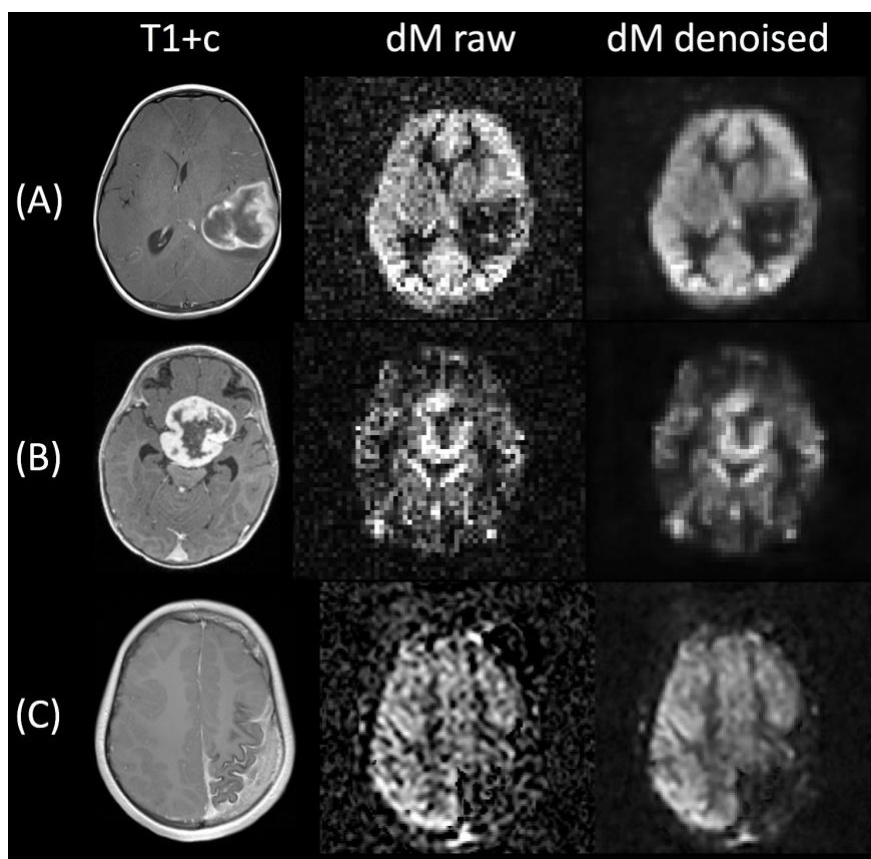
Clinical examples of implementation of the denoising autoencoder (DAE). T1-weighted images after injection of gadolinium contrast agent (T1+c) are shown in the left column. Raw pCASL dM images are shown in the centre column, with the equivalent denoised dM image shown on the right. Data shown in (A) and (B) were acquired at 1.5 T, data shown in (C) were acquired at 3.0 T. (A) 4 year old patient with a glioblastoma multiforme; (B) 0.9 year old patient with a pilocytic astrocytoma; (C) 11 year old patient with Sturge-Weber syndrome, demonstrating a cortical angioma and marked atrophy.
